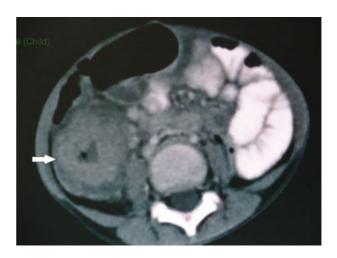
Computed tomography abdomen shows mass in the cecum (arrow).
